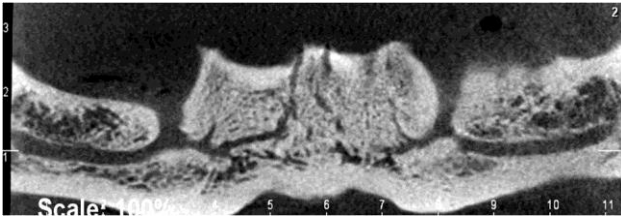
Mandibular incisive canal on CBCT scan
